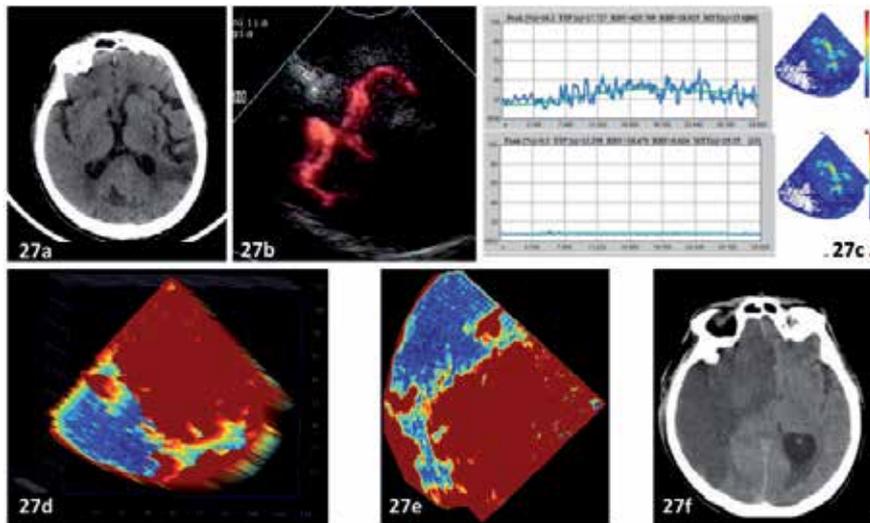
An example of Ultrasound Perfusional Imaging.
